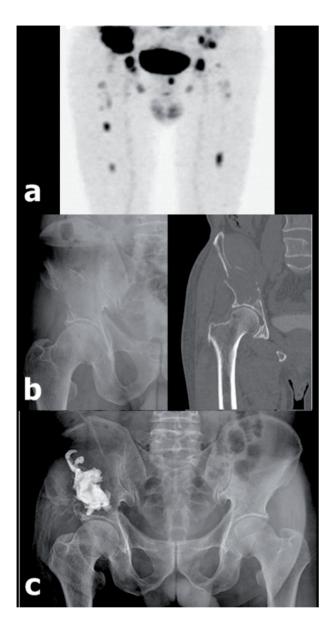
A 51 year old male patient with renal cell carcinoma and bone metastases. (a) Pelvis plain radiograph and CT scan shows left acetabular osteolytic lesion with cortical breakdown (b) Sufficient volume of PMMA without leakage was injected on postoperative pelvis plain radiograph and CT scan. (c) Reduction in F-18-FDG uptake at left acetabulum was observed on postoperative PET/CT in comparison with preoperative one.
